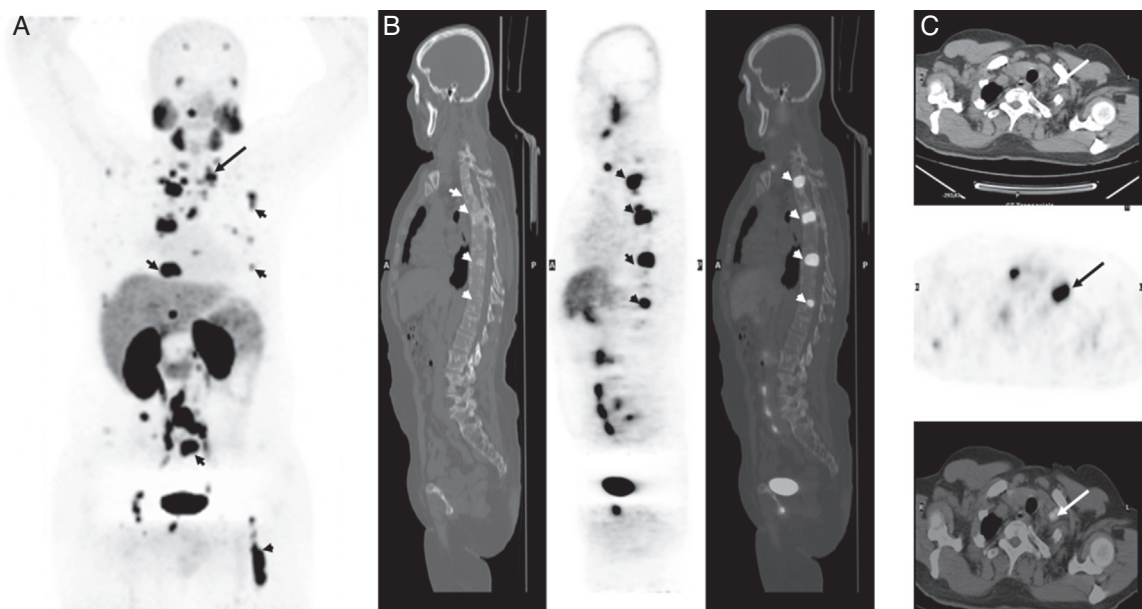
^{68}Ga -PSMA PET/CT showed supraclavicular lymph nodes (arrows) and widespread bone metastases (arrow heads) with high radiotracer uptake (SUVmax: 27) in PET maximal intensity projection (MIP), (B and C) sagittal and axial CT, PET and fusion images, respectively.
